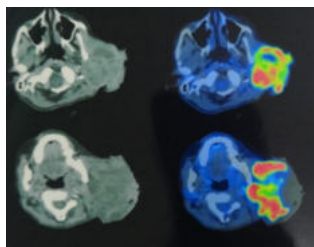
PET CT scan showing FDG avid lesion involving both superficial and deep lobes with extensive skin involvement and fungation.
